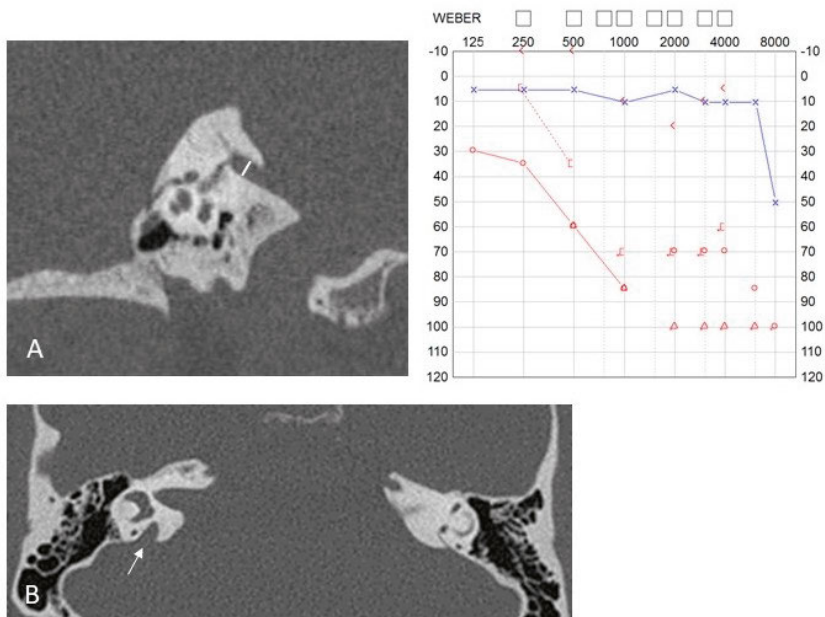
CT-scans (A, lateral and B, axial projections) and audiogram from an individual with unilateral (right-sided, arrow) severe hearing loss and LVAS.
